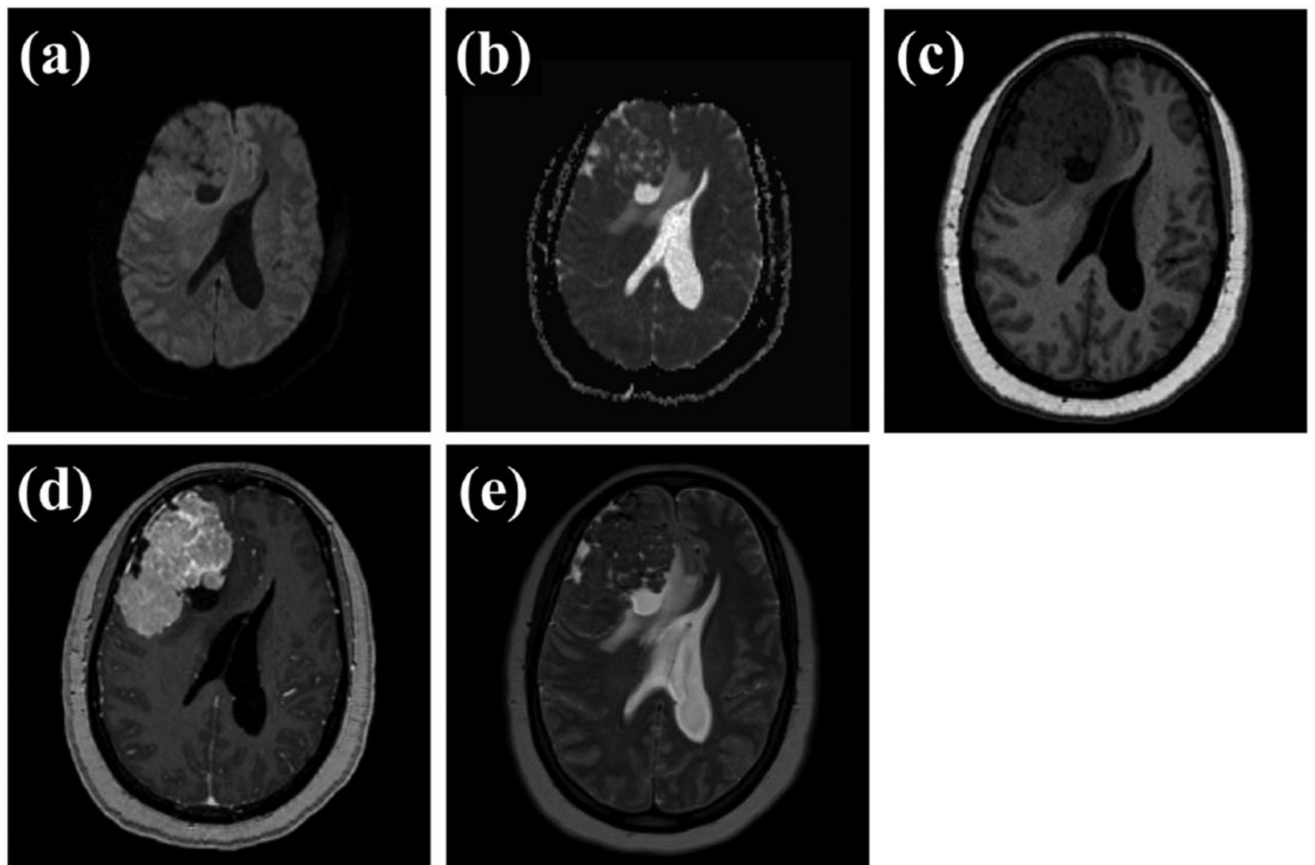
Axial magnetic resonance imaging (MRI) of the brain performed using a 1.5-T system. (a) Diffusion-weighted with trace weighting, (b) diffusion-weighted with apparent diffusion coefficient map, (c) T1-weighted precontrast, (d) T1-weighted postcontrast, and (e) T2-weighted fast spin echo postcontrast images. There is a large heterogeneously enhancing mass along the right frontal convexity. There are small cysts associated with this mass. There is relatively dark signal on apparent diffusion coefficient (ADC) and hypointensity on T2-weighted image, a characteristic of highly dense cellular tissue with high nuclear-to-cytoplasmic ratio such as can be seen with meningiomas.
